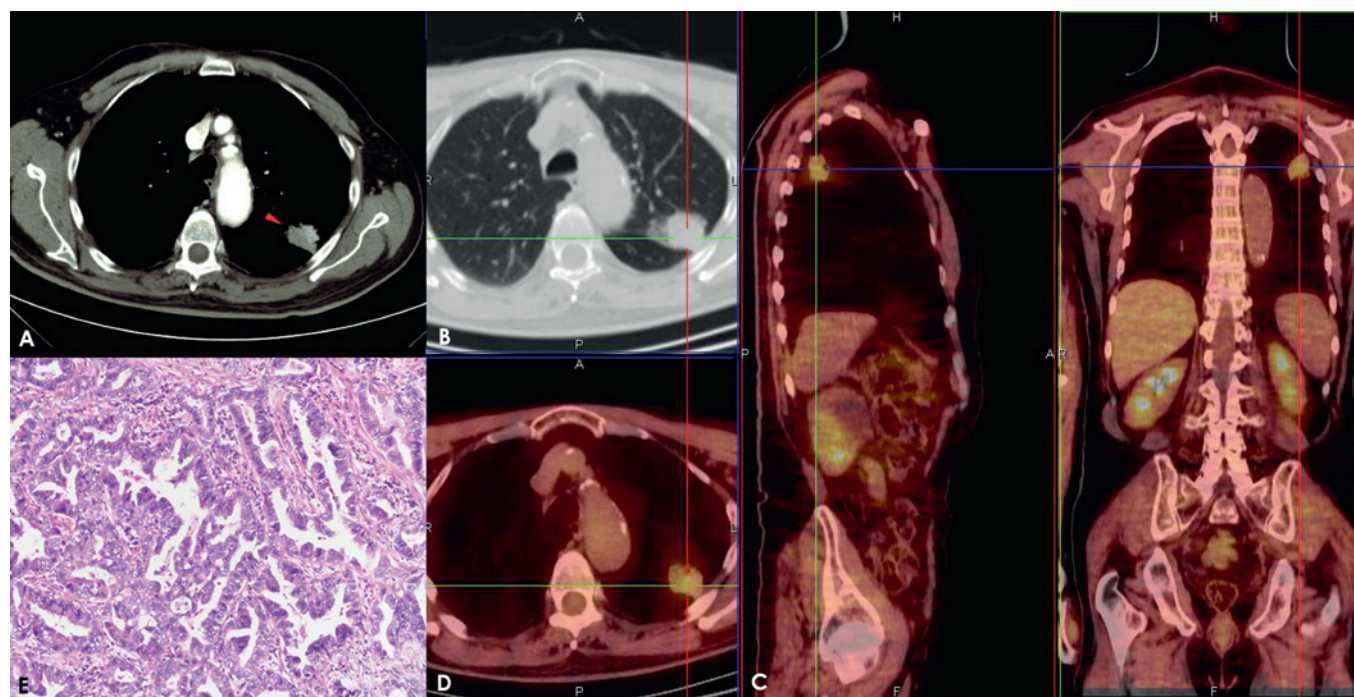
Adenocarcinoma in a 79-year-old man. Post-contrast CT axial scan shows a transverse thin section (2.0 mm collimation) on a 30 mm nodule (arrow) with spiculated margins (A,B). A superimposed region of interest on post-contrast images at 4 min shows an enhancement of 87 Hounsfield units (HU) and a net enhancement of 55 HU. The solitary pulmonary nodule has an area of [^{18}F]fluorodeoxyglucose uptake, with a maximum standardised uptake value of 2.55 units. The positron emission tomography image integrated with the CT image to obtain fusion images on axial sagittal and coronal planes shows the captation site (C,D). This lesion was classified as a moderately differentiated (G2) adenocarcinoma with rich vascularity, moderate necrosis, low hypercellularity and moderate connective stroma (E).
